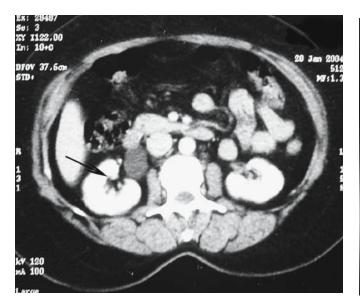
A CT urogram shows a normal lower moiety (arrow)
